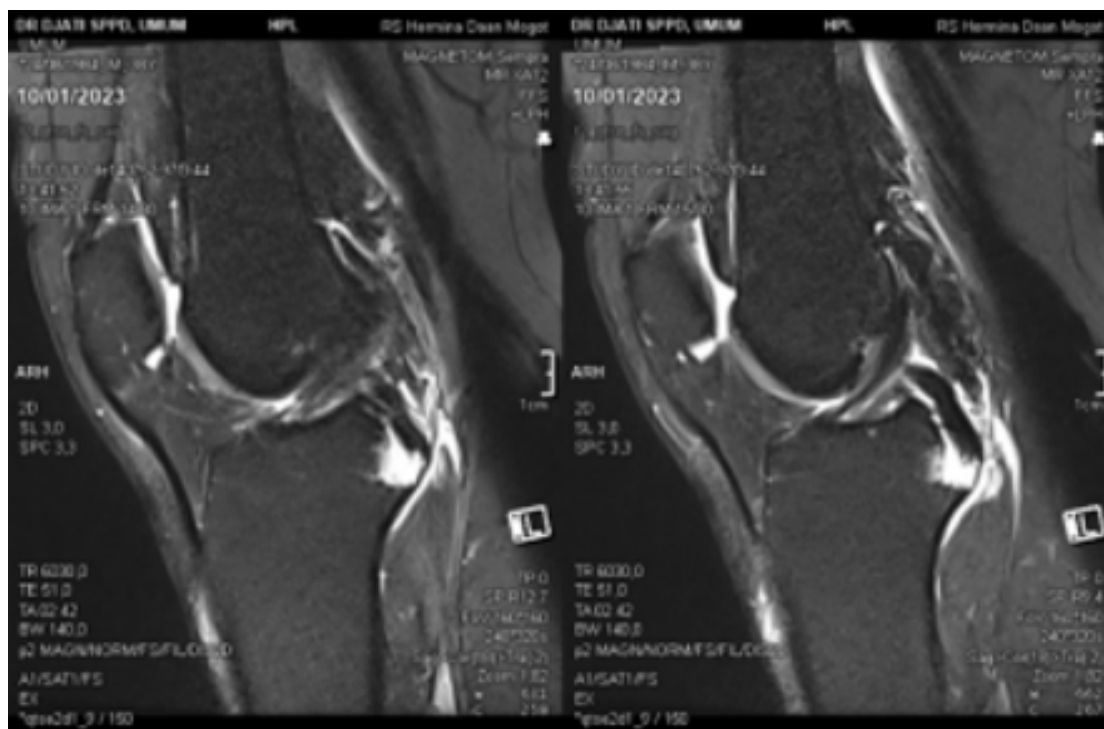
Sagittal MRI of the right knee showing bone marrow edema with tear and retraction of the PCL.
